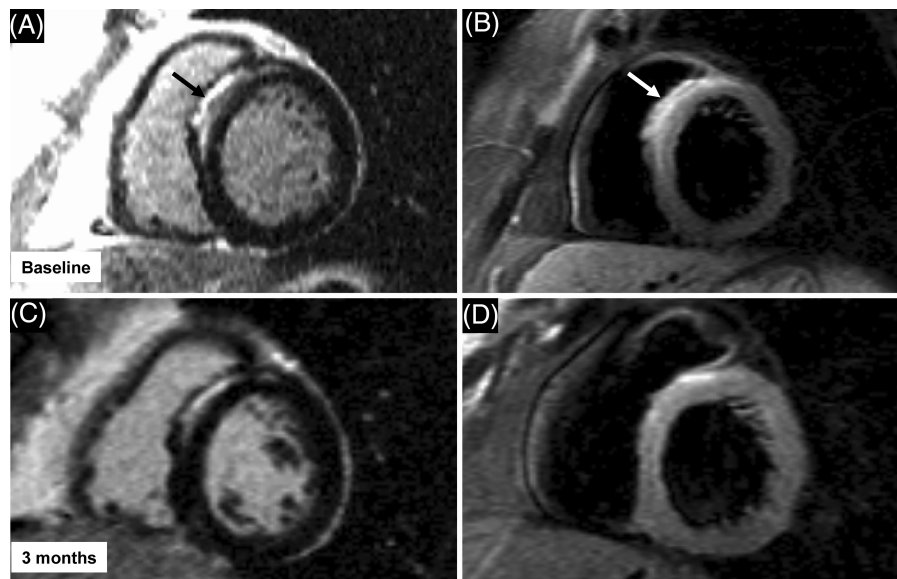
Resolution of myocardial inflammation but persistent fibrosis in myocarditis. (A and B) Gadolinium-enhanced and T2-weighted images at baseline, respectively. Epicardial late enhancement can be seen in the anteroseptal wall in (A) with corresponding increased signal on the T2-weighted image in (B) (arrows). A repeat scan 3 months later shows persisting fibrosis (C) but diminished signal on T2-weighted images, indicating resolving inflammation (D).
